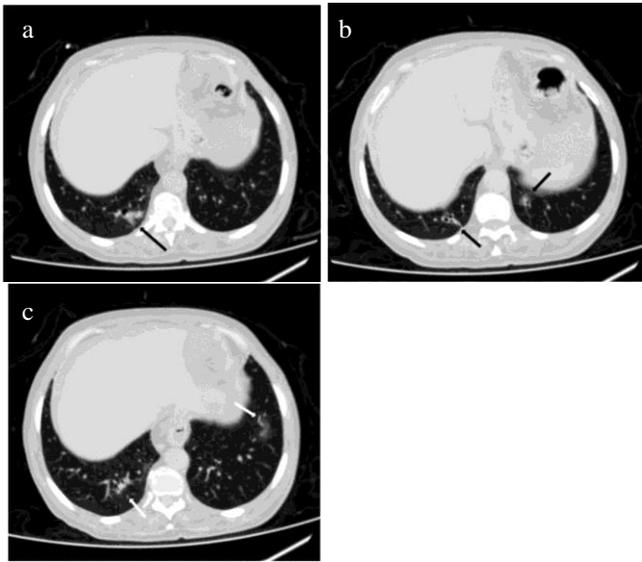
69-year-old female patient who presented with lack of appetite, diarrhea, and abdominal pain. Axial abdominopelvic CT images with lung windows (a, b, c) demonstrate bilateral, peribronchovascular ground-glass nodules and opacities in lower lobes (arrows). After abdominal CT findings raised concern for COVID-19, the patient was found positive for coronavirus disease.
